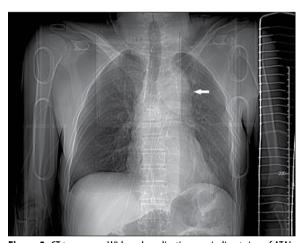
CT topogram. Widened mediastinum — indirect sign of ATAI (arrow).
